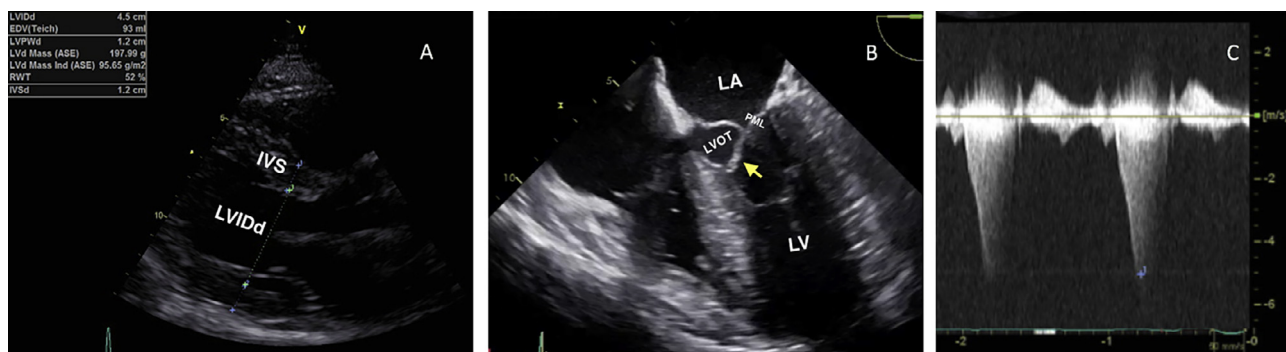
Echocardiography showing SAM. (A) Trans-thoracic echocardiographic imaging in the parasternal long-axis view showing concentric remodeling of the left ventricle (LV). (B) Transesophageal echocardiography. Mid-esophageal four-chamber view showing a systolic anterior motion of the anterior mitral leaflet (yellow arrow) into the left ventricular outflow tract (LVOT) causing severe LVOT obstruction at rest with gradient of 98 mmHg by continuous wave Doppler (C). IVS = interventricular septum; LA = left atrium; LVIDd = left ventricular internal diameter end diastole; PML = posterior mitral leaflet.
